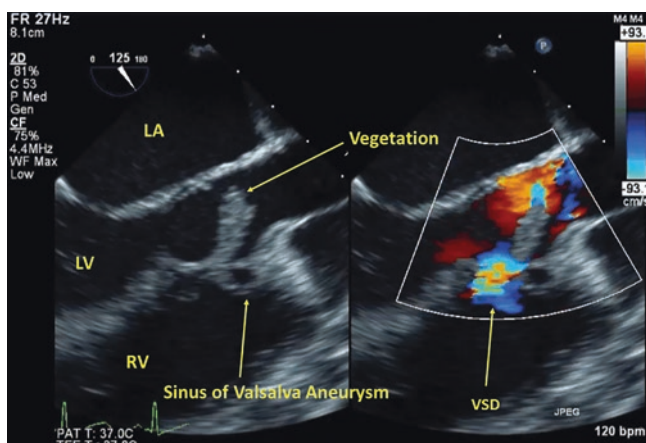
Case #1. Sinus of Valsalva aneurysm formation from infective endocarditis, as seen from a color Doppler image of a midesophageal aortic valve long axis view. Color Doppler shows that there is left to right shunting across a ventricular septal defect (VSD). LA left atrium, LV left ventricle, RV right ventricle, VSD ventricular septal defect
